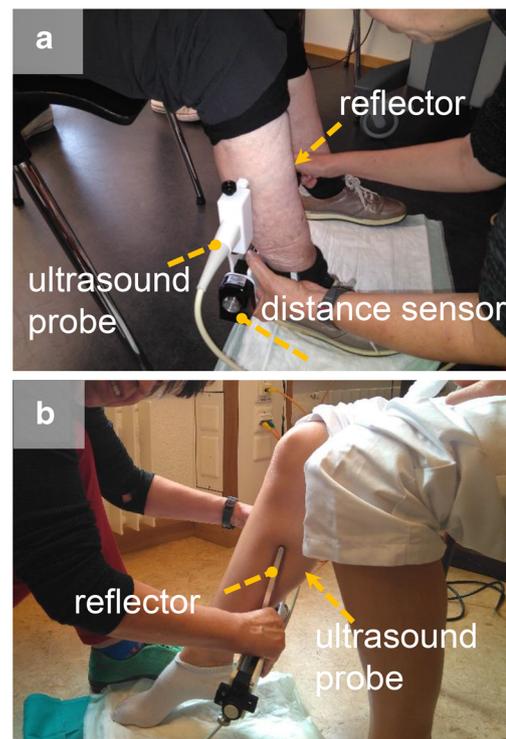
Concept of hand-held speed-of-sound (SoS)-US [23]. A positioning frame connects the probe with the reflector and allows distance measurements via a digital sensor. Ultrasound gel was applied on both the US probe and reflector surfaces to assure sufficient coupling with the calf. a Demonstrates the setup for an elderly female and (b) for a young female
